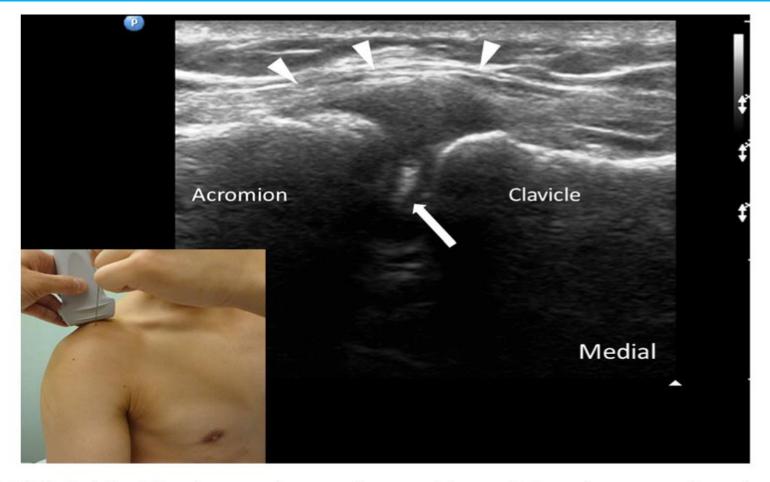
The insert shows the position of the ultrasound probe and the needle with the out-of-plane technique. The corresponding ultrasound image shows the ACJ with the image of the needle (solid arrow). The arrows outline the superior joint capsule. Reprinted with permission from usra.ca.
